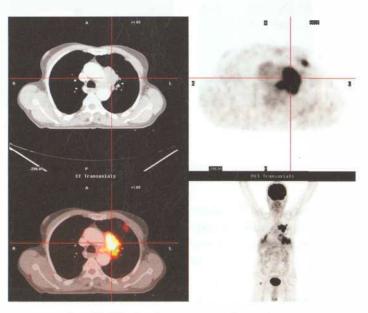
22: Carcinoma lung—PET-CT scan
